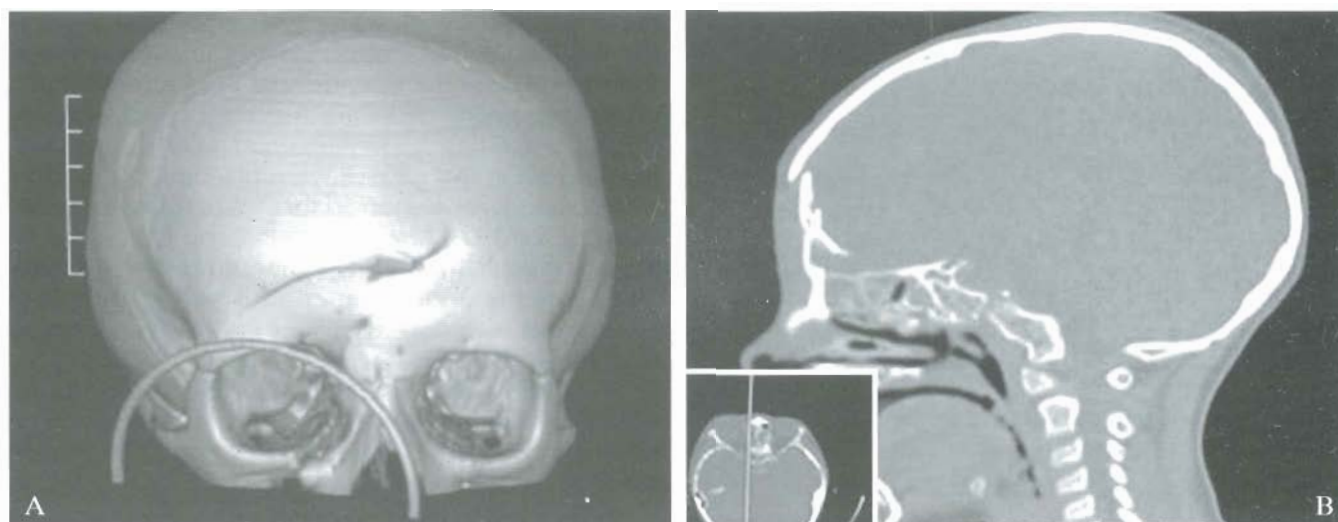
Preoperative computed tomographic scan demonstrating frontal and orbital-zygomatic-maxillary fractures. CT 3D (A), sagittal view scan (B).
